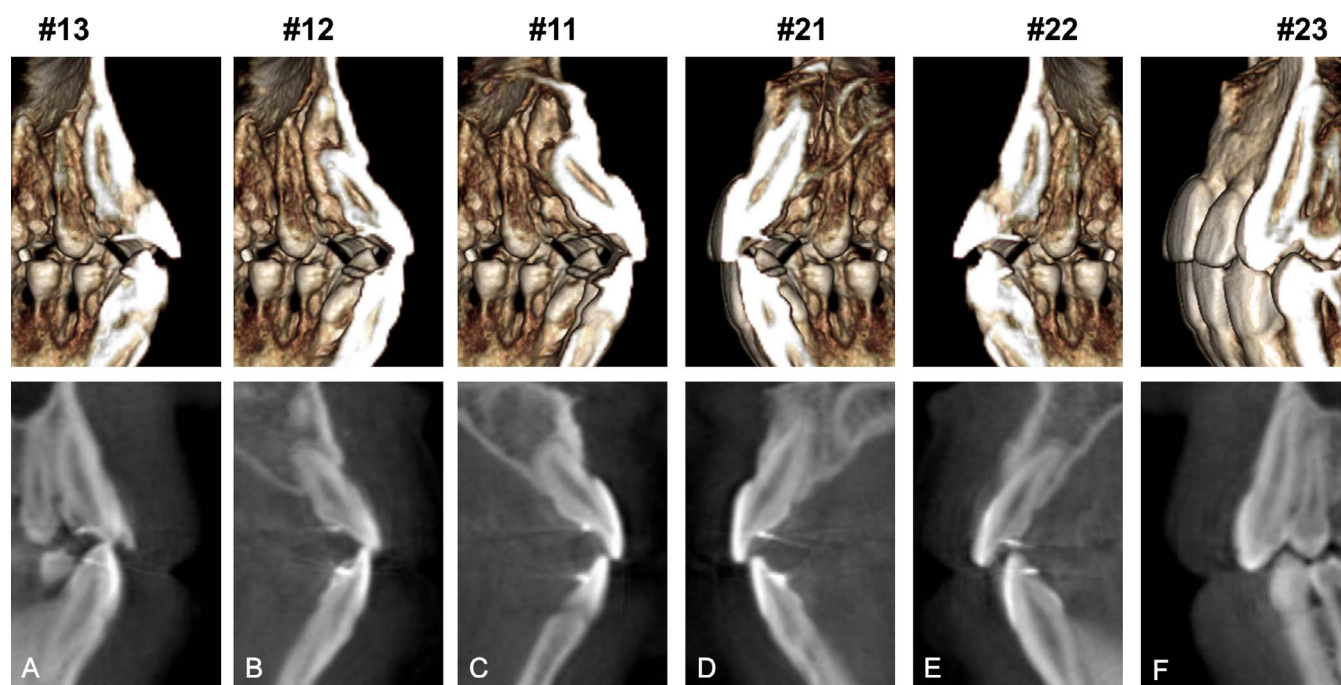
Three-dimensional cone-beam computed tomographic sagittal images of upper six anterior teeth after treatment.
